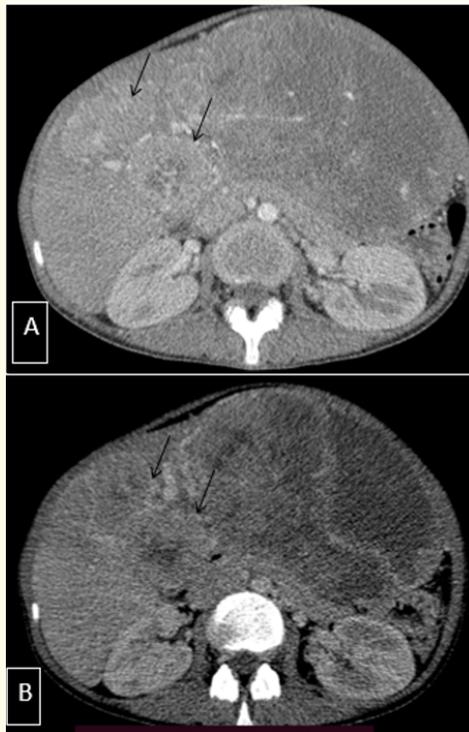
Abdominal C + CT, arterial phase (A) and portal phase (B): other hepatic localization in segment V (arrows) similar to the hepatic mass of the left liver.
